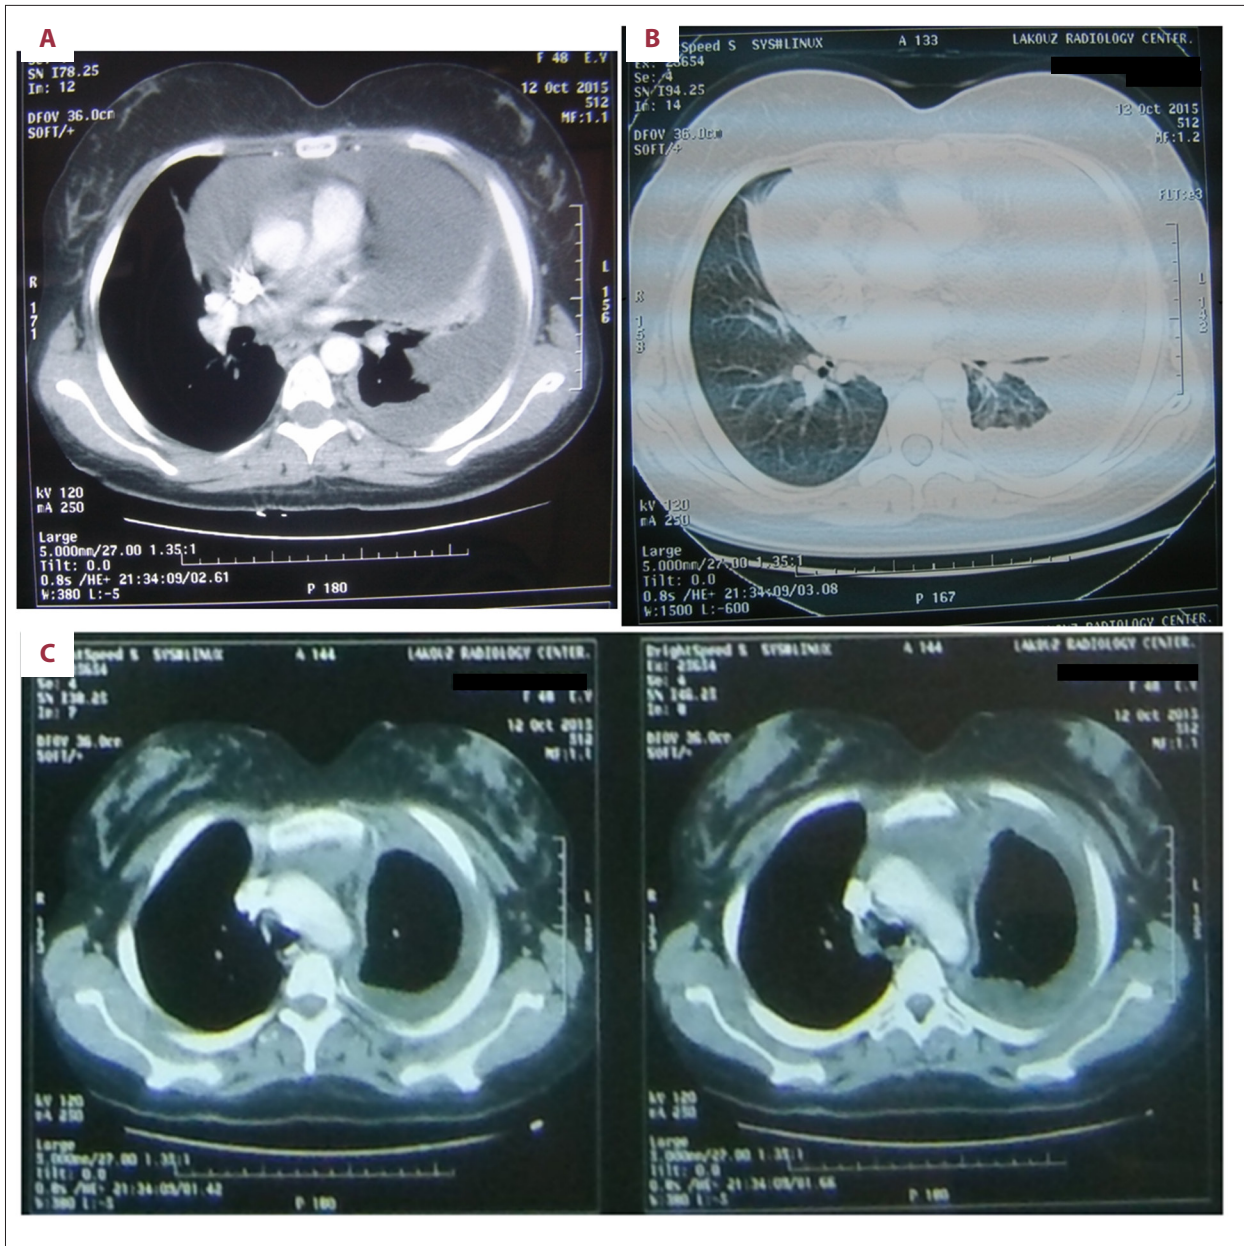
(A, B) Mediastinal lung windows of axial chest CT scan showed left side pleural effusion and pericardial effusion without parenchymal abnormality. (C) Axial enhanced CT image of the thoracic aorta showed minimal periaortic infiltration involving the aortic arch.
